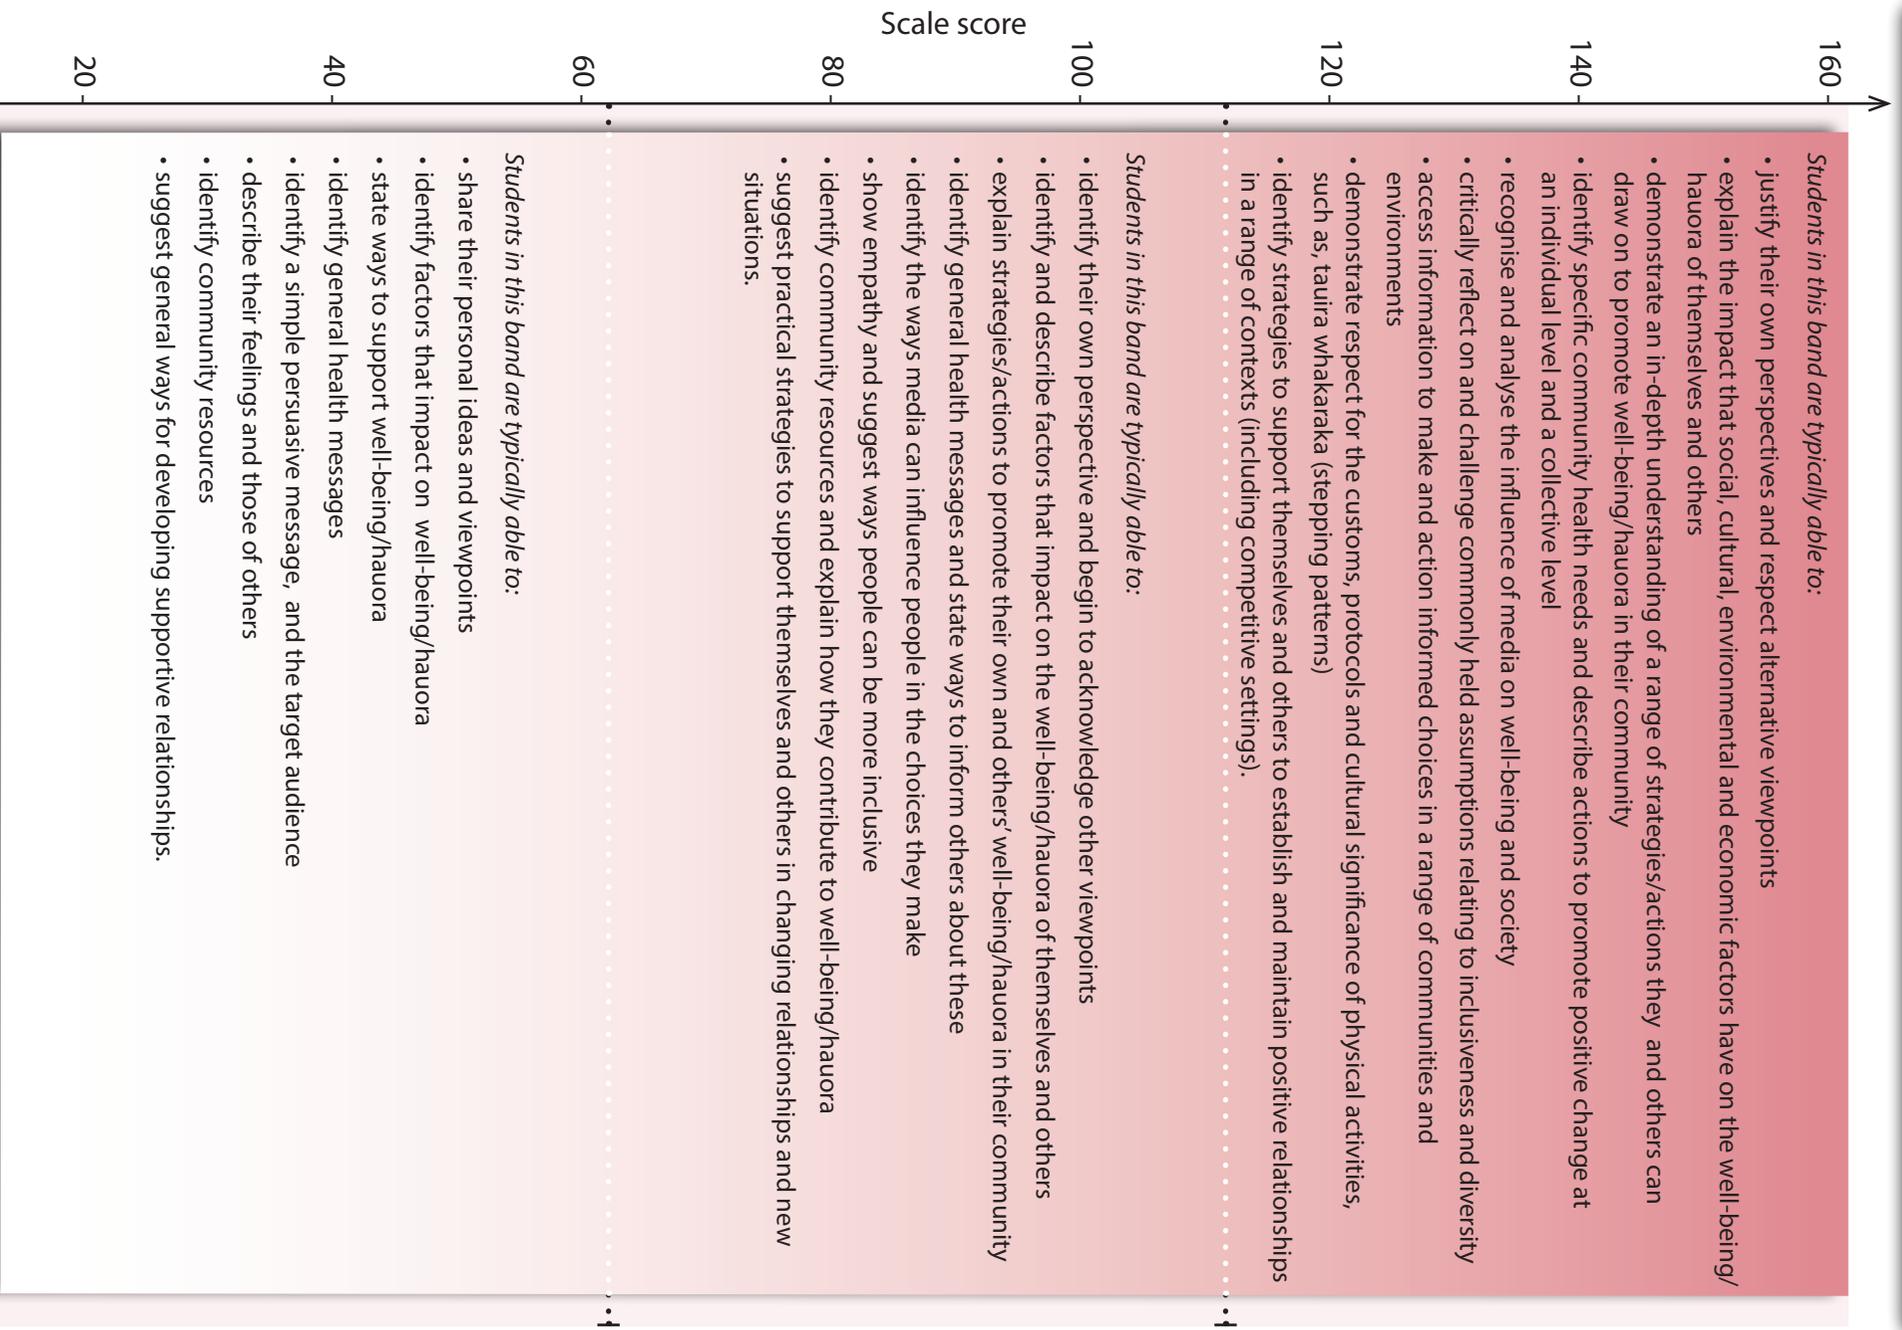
NMSSA Critical Thinking in HPE (CT) Scale
